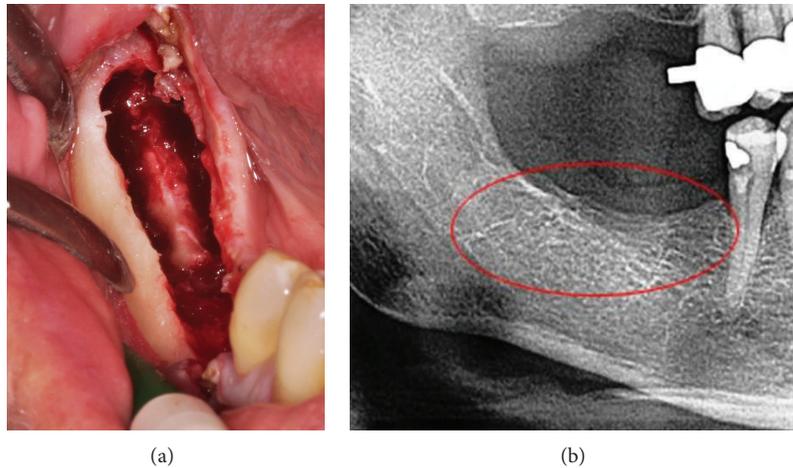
Curettage of FDOJ in the lower jaw with denuded infra-alveolar nerve. Corresponding X-ray without any signs of pathological process in jawbone (b).
